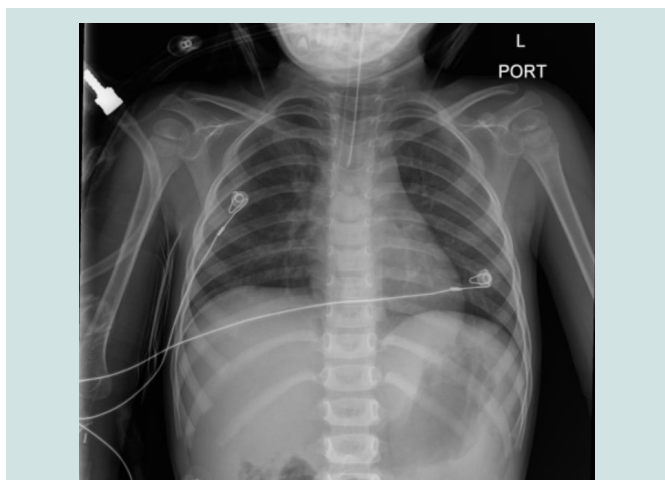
Initial chest X-ray after intubation at Children's Hospital.
